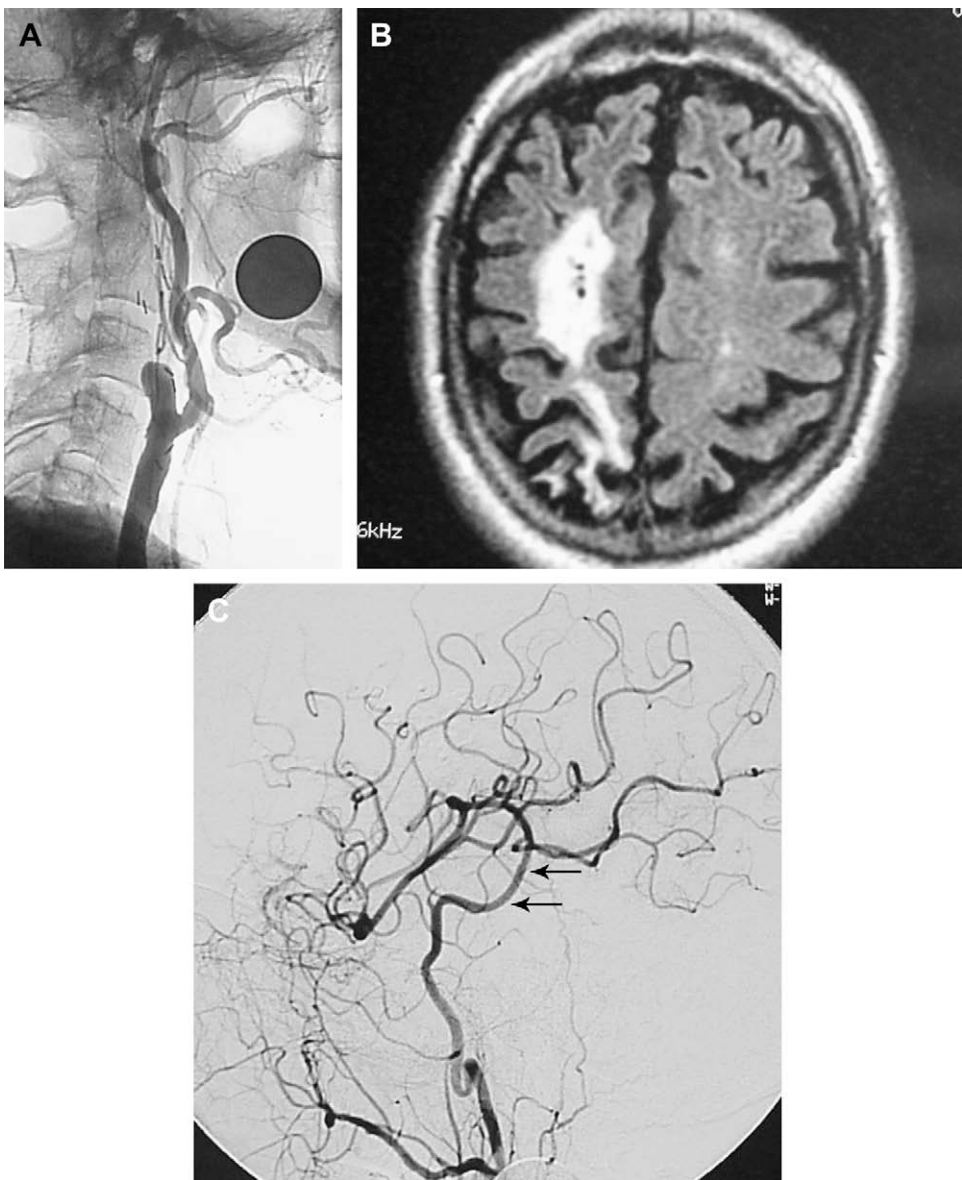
Right carotid occlusion after a prior carotid endarterectomy presenting with stroke. (A) Lateral carotid angiogram demonstrates the occluded ICA. (B) Axial MRI demonstrates a typical watershed area stroke in the right hemisphere despite medical therapy. Perfusion testing with xenon CT confirmed loss of cerebrovascular reserve in the right hemisphere, and the patient underwent right STA-MCA bypass. (C) Postoperative lateral angiogram demonstrating excellent filling of the MCA territory by the widely patent STA bypass (arrows).
